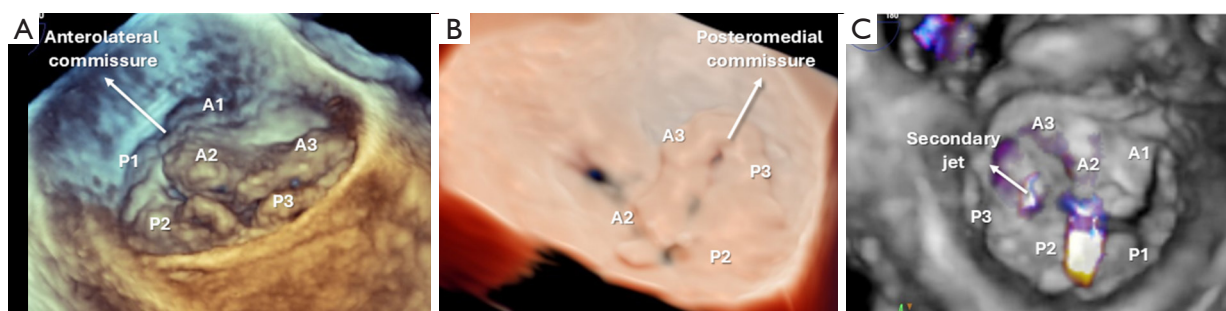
Modified en-face views of the mitral valve. (A) 3D TEE modified en-face posteromedial view from the LA perspective, demonstrating bileaflet prolapse. The direction of view is from the posteromedial toward the anterolateral commissure. (B) Tissue realistic 3D TEE modified en-face anterolateral view from the LA perspective, showing prolapse of A3, P3 and the posteromedial commissure. The direction of view is from the anterolateral toward the posteromedial commissure. (C) 3D TEE color flow Doppler modified en-face view from the left ventricle perspective, demonstrating two jets of MR. The secondary jet of MR located between A3-P3 was obscured by the main jet of MR and not identified from the left atrium perspective. 3D, three-dimensional; LA, left atrium; MR, mitral regurgitation; TEE, transesophageal echocardiography.
